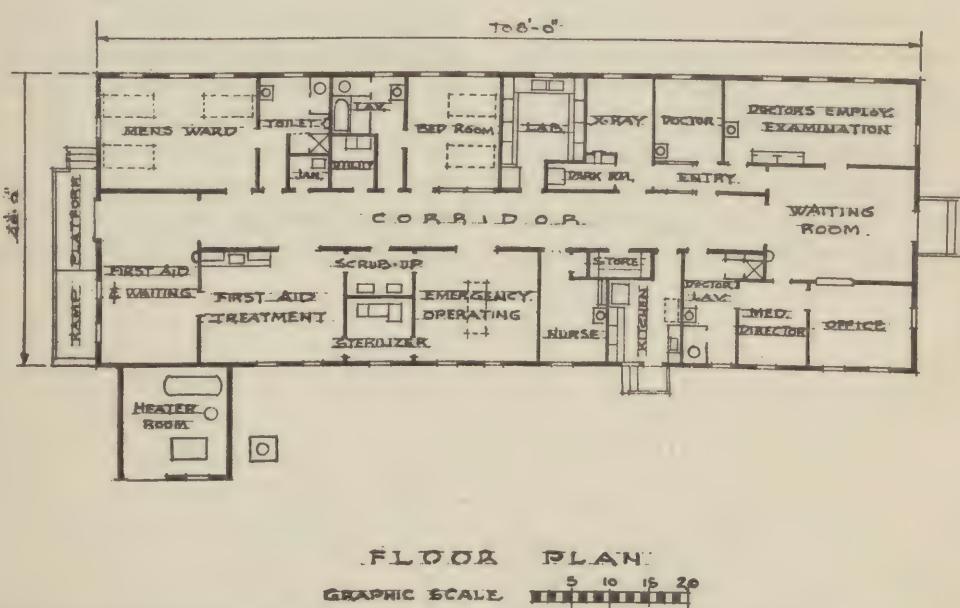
and 10 show floor plans of standard U. S. Army industrial dispensary buildings. (See frontispiece for exterior view of typical construction.) Two main types of structures are recommended, 108' by 40' and 140' by 40'. These dispensaries are suitable for the central medical department of an industrial installation and have proved to be generally adequate for installations ranging from 2,000 to 15,000 employees. The basic plan from which these buildings are drawn is capable of expansion when and if necessary. It will be noted that one of the main differences between the two floor plans is the size of the X-ray rooms. Generally speaking, an X-ray is a valuable and a necessary adjunct to industrial medical practice. Depending upon the number of employees and the type of industry at the installation, a larger or smaller X-ray machine is required.
